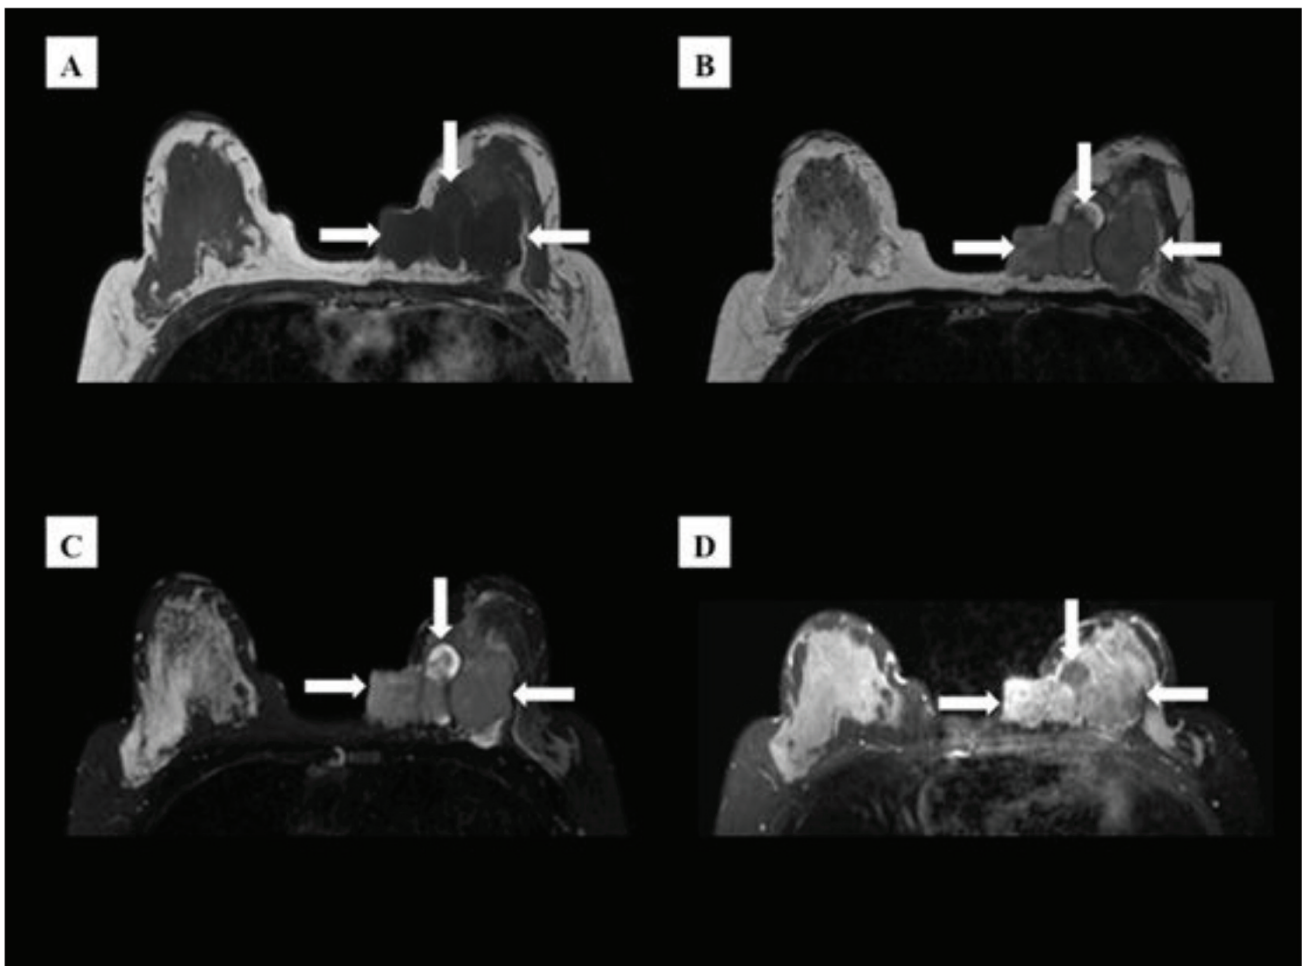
Axial images of both breasts by magnetic resonance imaging (MRI) in T1W (A), T2W (B), SPAIR (C) and post-gadolinium administration (D). There were 3 well-defined lobulated masses (white arrows) in the posteromedial aspect of the left breast. These masses demonstrated hypointense signals on T1W sequence and heterogeneous signals on T2W/SPAIR sequences compared to the breast parenchyma and heterogeneous enhancement post-contrast.
